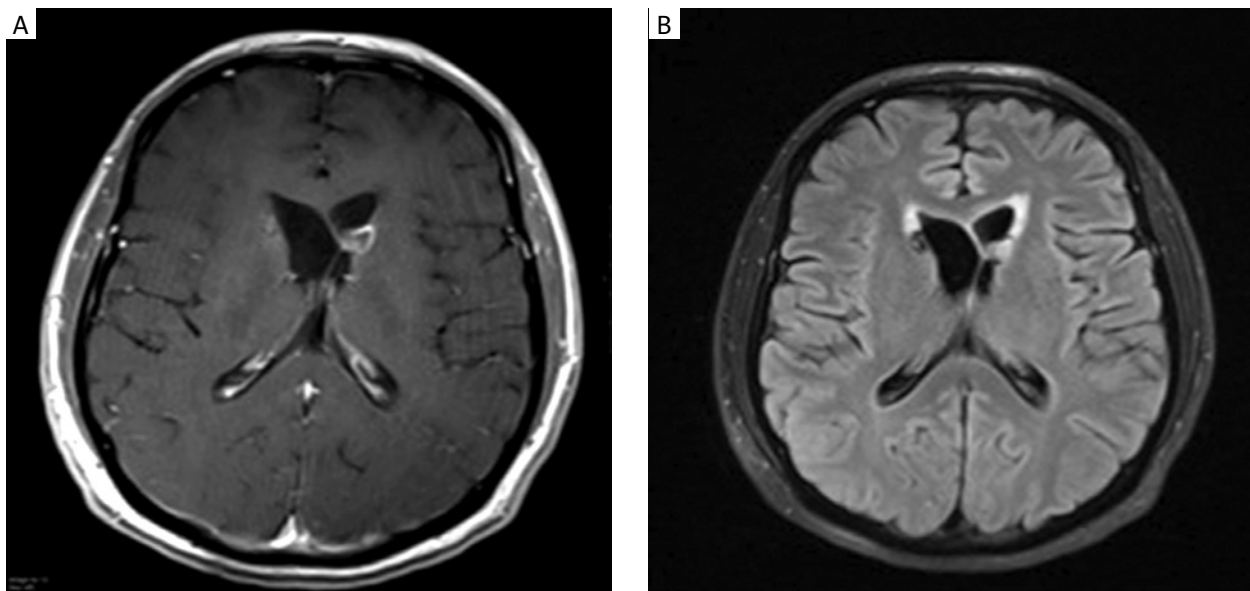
Two-month follow-up brain MRI. Prominent reduction of the lesions: small ring-enhancing lesions (A: axial T1 GAD), with minor gliosis and/or edema (B: axial T2 FLAIR)
